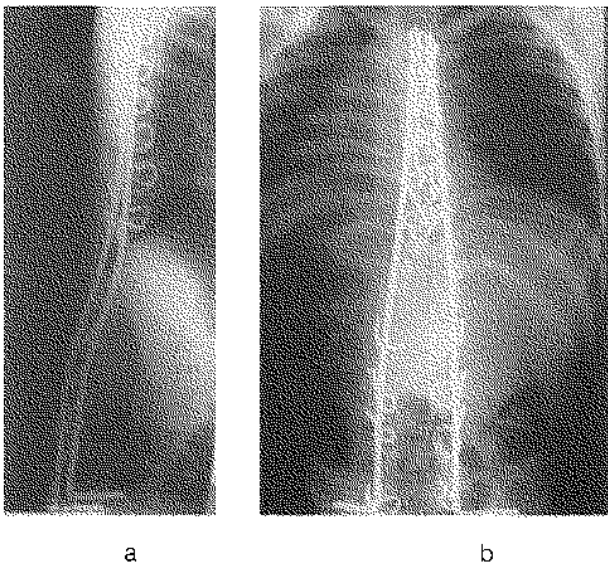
Case 1. Postoperative lateral (A) and AP (B) roentgenographs.
